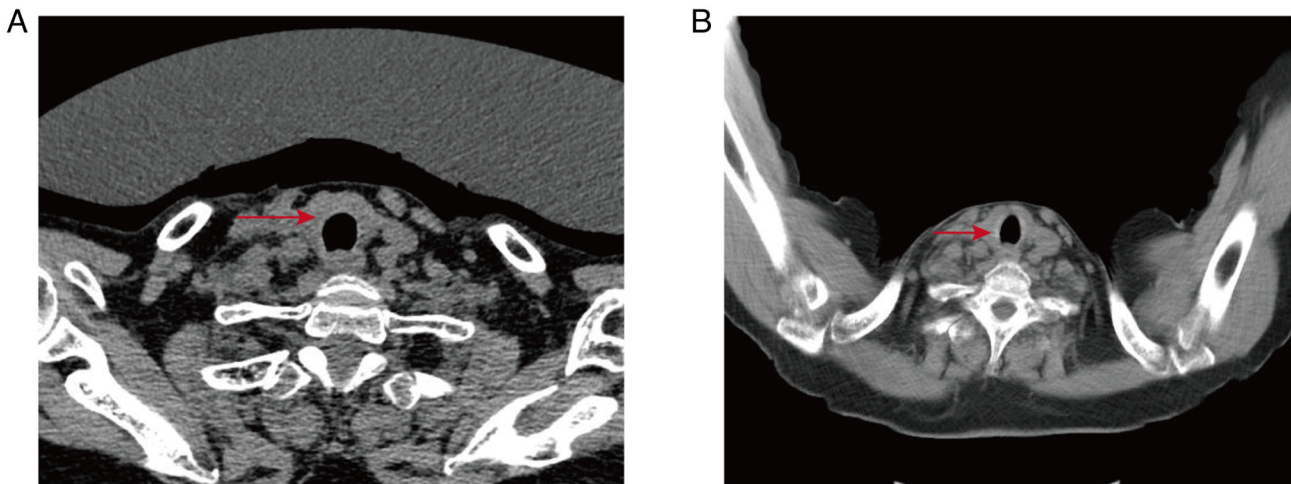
Imaging after chemotherapy. (A) CT scan in December 2024. (B) CT scan in February 2025. The red arrow indicates the restored trachea.
